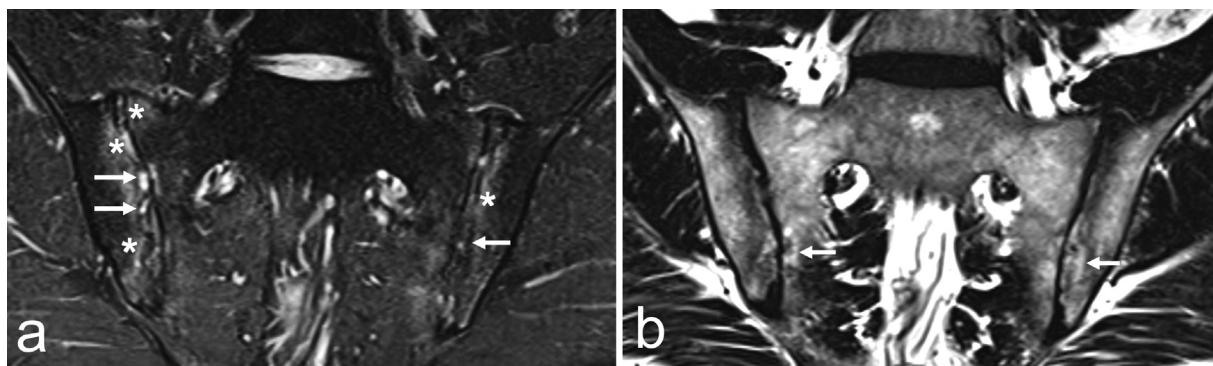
A 34-year-old man with axial spondyloarthritis. Coronal oblique (a) water-only and (b) fat-only images of a single T2-weighted Dixon show bone marrow edema-like signal intensity (a, white asterisks), subchondral erosions (a, arrows), and fat metaplasia (b, arrows). The T2-weighted Dixon technique enables accurate depiction of signs of disease activity and structural bone changes in a single acquisition.
